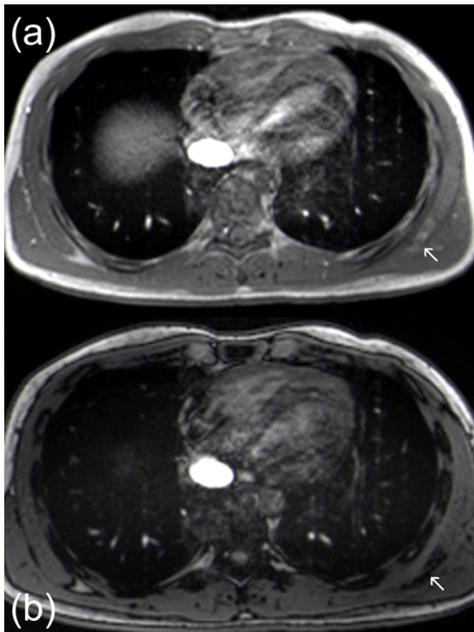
Elastofibroma Dorsi (arrow) of left infrascapular region on MRI- in and out phase sequence. In (a) and out (b) phase sequence showing India ink artifact on out phase, consistent with the fatty content of the lesion.
